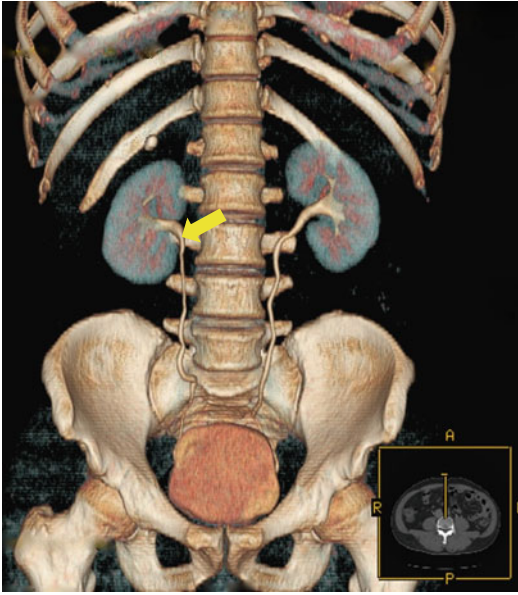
3D CT Scan reconstruction of the urinary tract. The ureteropelvic junction (UPJ) is identified (yellow arrow)
